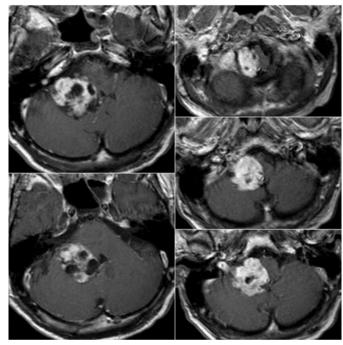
MRI showing a right cerebellopontine angle tumor with heterogeneous contrast enhancement.
